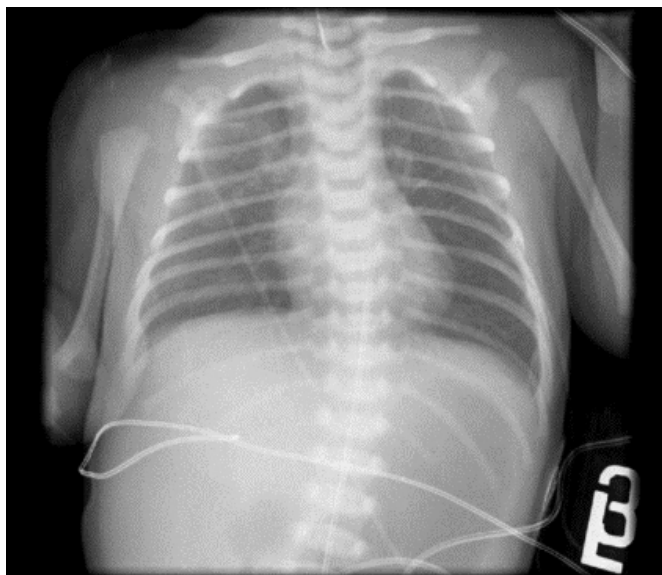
Chest radiograph demonstrates a distended gas-filled stomach, and a Replogle tube in the esophagus which met resistance at the proximal esophageal pouch at the level of the clavicle.
